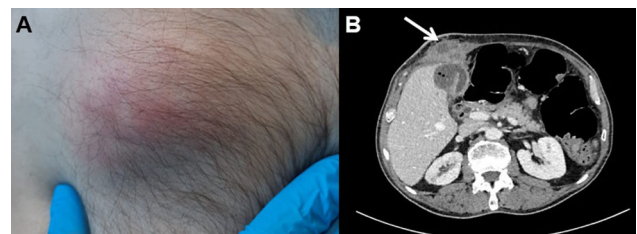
(A) Painful, erythematous mass in the right upper quadrant. (B) Axial contrast-enhanced computed tomography (CT) scan showing an irregular perihepatic collection extending into the subcutaneous tissue, as indicated by the white arrow.
